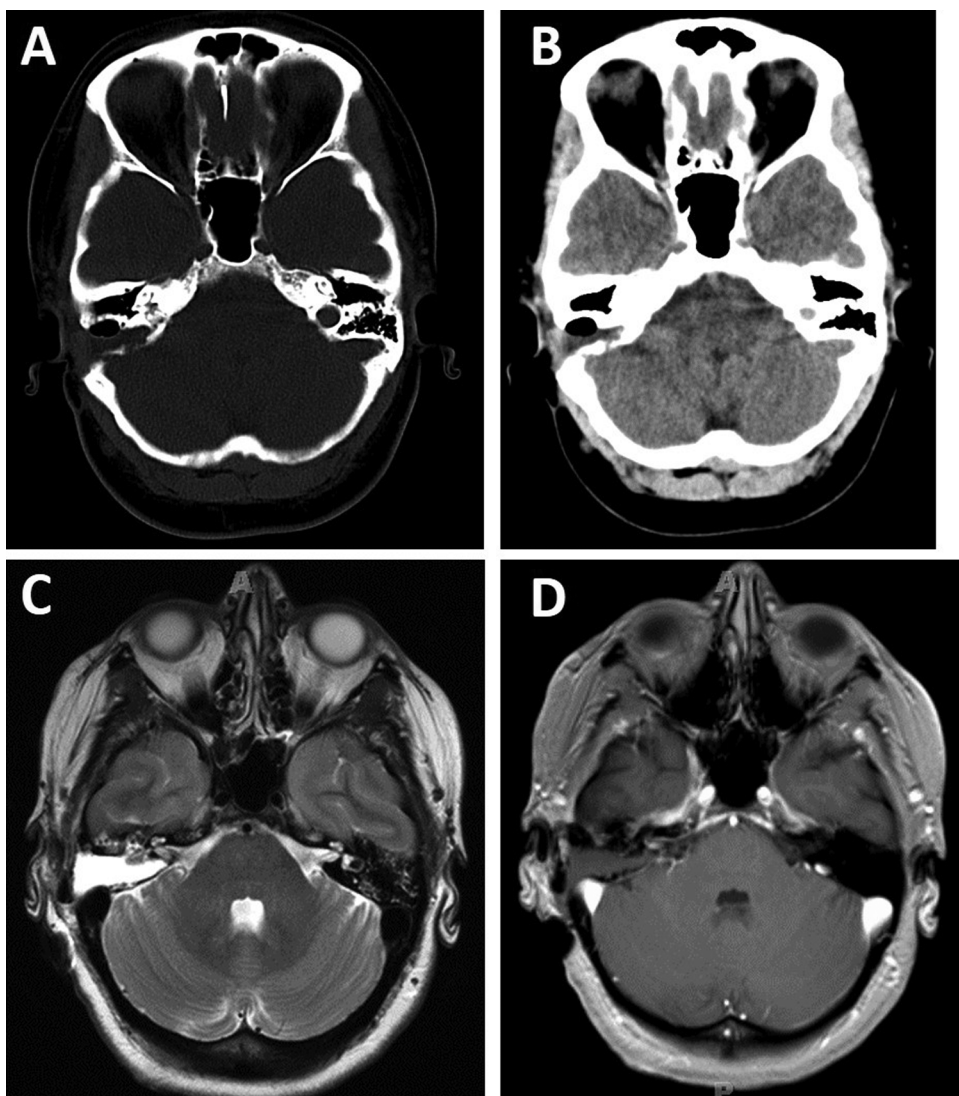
A and B: Postoperative CT showing changes of mastoidectomy with expected post-operative air-fluid level in the mastoidectomy cavity. There was complete surgical resection of the lesion. C: T2 weighted MRI showing postoperative changes of mastoidectomy with fluid in the resection cavity. D: Post-operative CE-T1 weighted MRI shows no residual enhancing tissue. The dural sinuses are patent.
